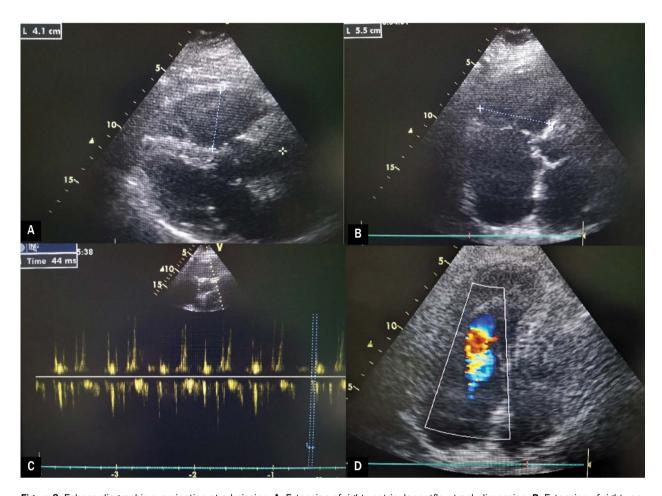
Echocardiographic examination at admission: A. Extension of right ventricular outflow track dimension; B. Extension of right ventricular inflow track dimension; C. Shortened pulmonary artery acceleration time; D. Significant tricuspidal regurgitation
